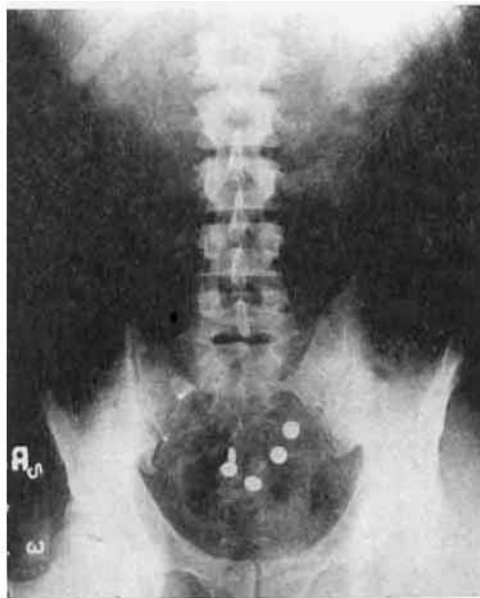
A Photograph of a Roentgenogram of the Same Individual as Is Shown in Fig. 5, but Taken Four Hours Later. All of the Tablets Are Now in the Intestines.
